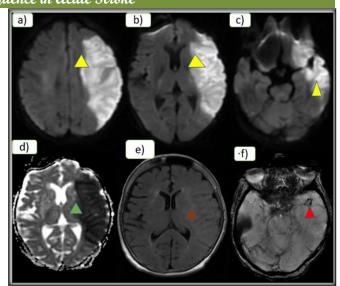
(a-f)- Showing Acute infarct in MCA territory with susceptibility sign in left MCA. Fig 3a-3d demonstrating true diffusion restriction (Yellow arrow heads) in left frontotemporo-parietal lobes and left lentiform nucleus. Fig 3e, demonstrating the FLAIR hyperintensity (brown arrow head) in the involved region. Fig 3f, demonstrating the susceptibility sign (Red arrow head) with thrombus in the M1 and M2 segment of left MCA.
